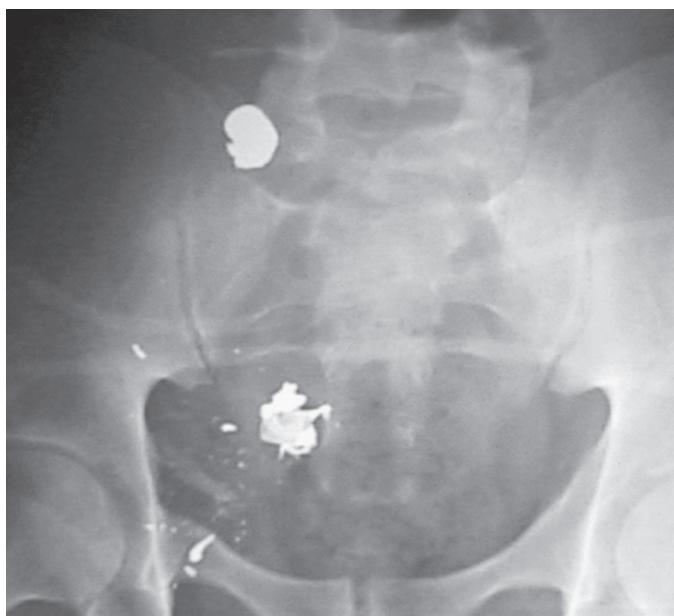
The pelvic location of the missile on the abdominal radiograph, combined with hypotension, is highly suggestive of an iliac vascular injury.
